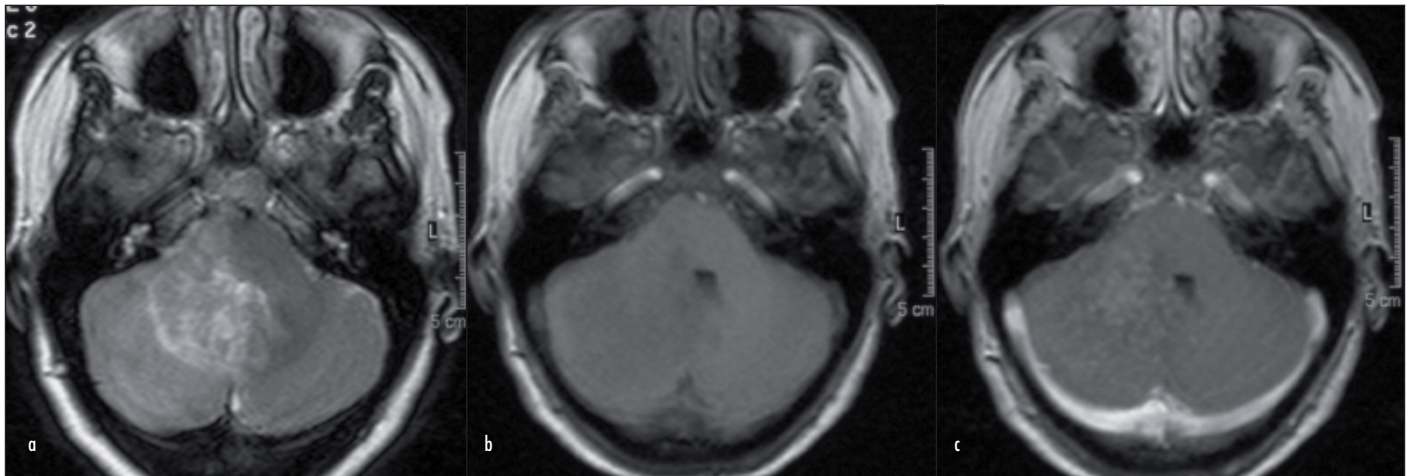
a, T2, (b) T1 and (c) T1 post gadolinium axial magnetic resonance imaging scan.
